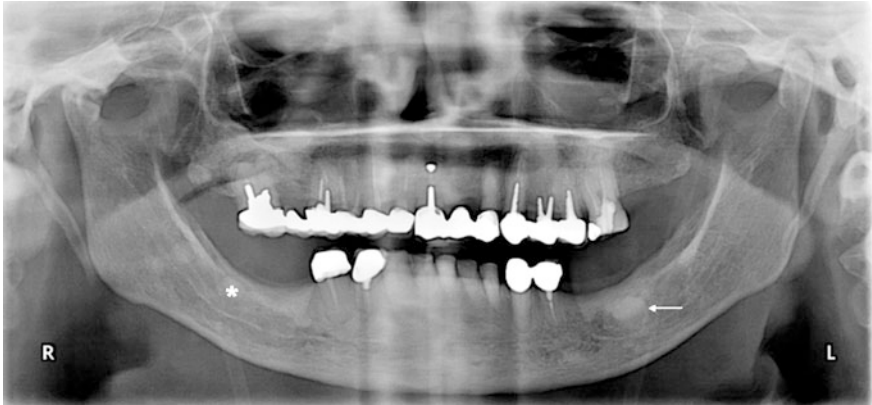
Orthopantomography: sign of endodontic treatment and partially edentulous lower arch. Note the well-defined oval radiopaque lesions in the region of *right* (asterisk) and *left* (arrow) mandibular molars
